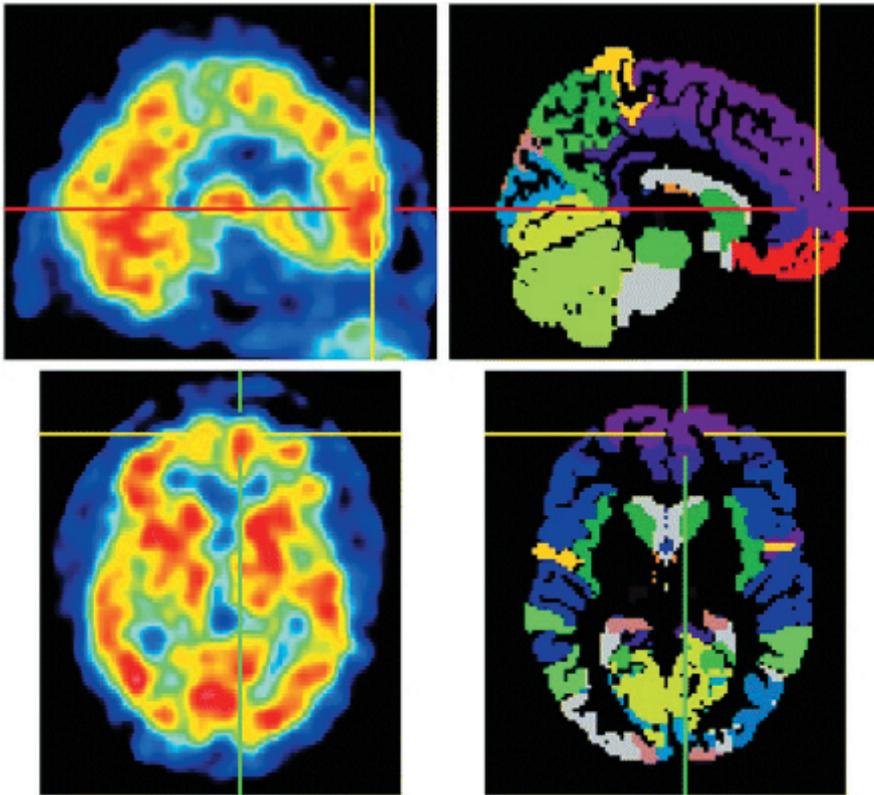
Regional cerebral blood flow on sagittal and transversal SPECT slices of a patient with T2DM (left) with corresponding slices of International Consortium for Brain Mapping template (right) (Kaplar et al., 2009)
